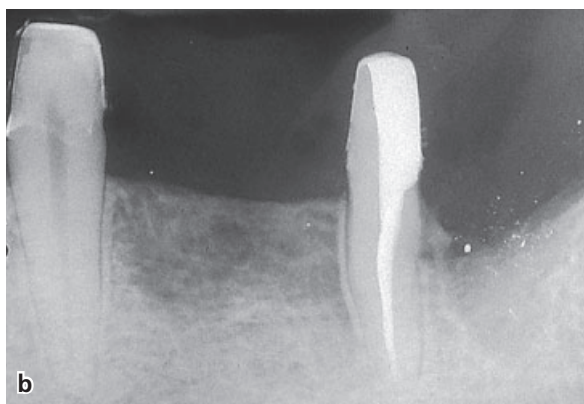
(a) Radiographs of a mandibular first molar to be extracted and of a second molar to be root resected. (b) During hemisection an overhang is left behind as a result of an oblique sectioning of the tooth distal to the furcation. (c) In a radiograph obtained 2 years later, the presence of an angular bony defect can be seen adjacent to the "overhang". The lesion was resolved and the angular defect disappeared following removal of the "overhang". (d) Radiograph after 2 years.
